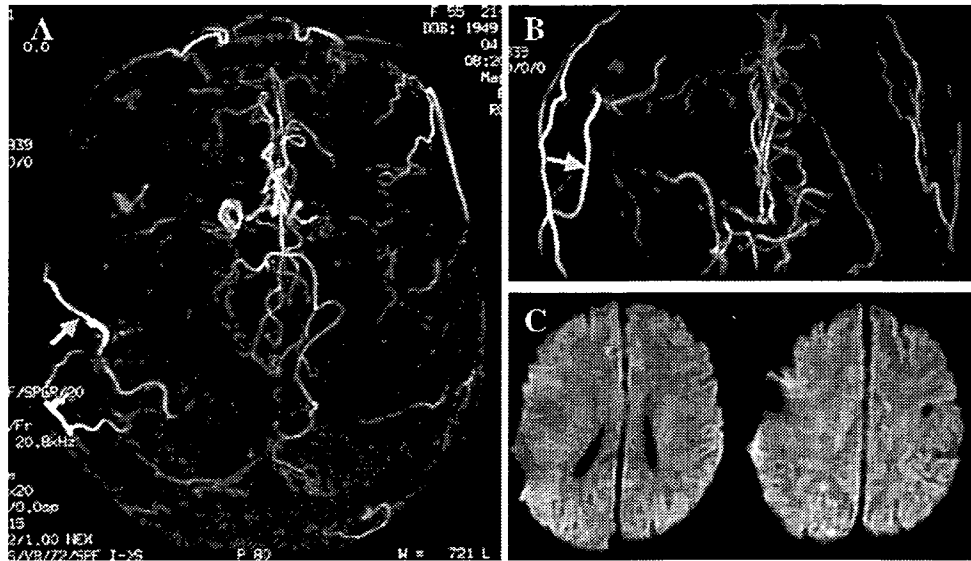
Case 1. Postoperative MRA showing the apparently patent STA-MCA bypass as a higher intensity signal than the opposite side STA (arrows in A and B). C: Diffusion-weighted MR images 2 days after surgery, showing no evidence of ischemic change.
